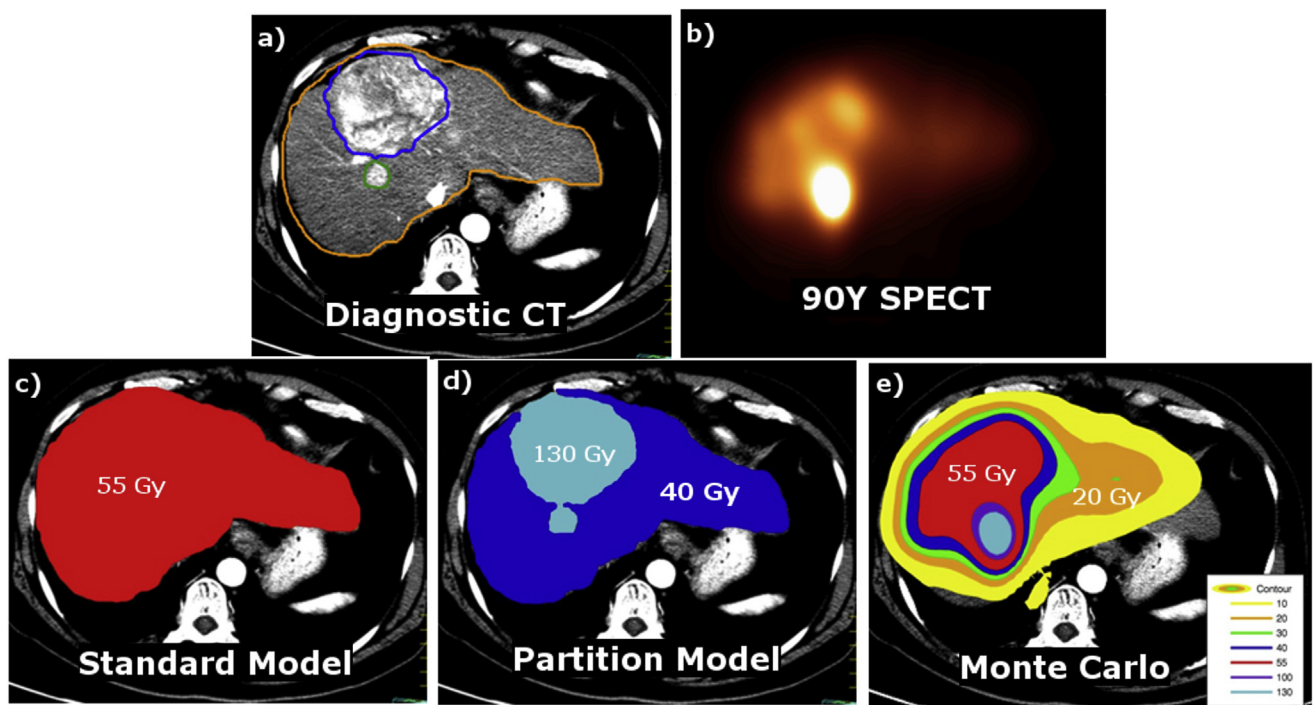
Spatial representation of the dosimetry models. (a) Diagnostic computed tomography (CT), (b) ^{90}Y single photon emission computed tomography (SPECT), (c) standard model, (d) partition model, (e) Monte Carlo. Gold, blue, red, and cyan color washes represent 20, 40, 55, and 130 Gy, respectively. (A color version of this figure is available at www.redjournal.org.)
